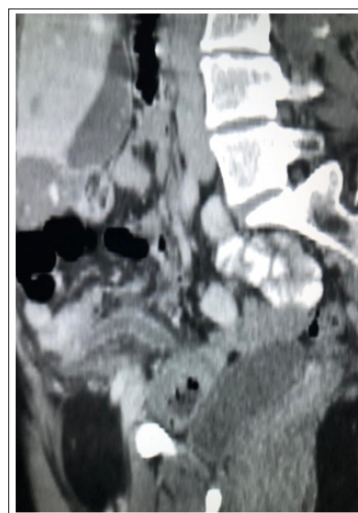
Axial and Coronal Computed Tomography. Acute Appendicitis and Carce Adjacent Free Fluid
